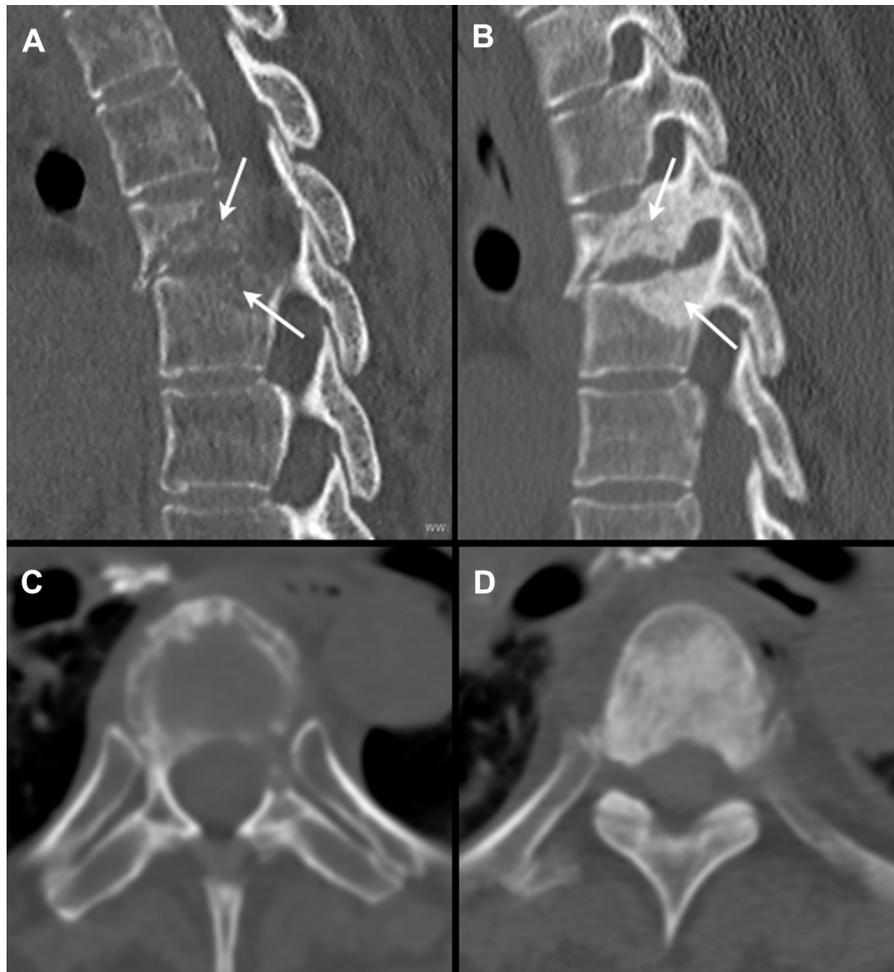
(A) Sagittal and (C) axial computed tomography (CT) scans of the thoracic spine performed 6 weeks before the attempted vertebroplasty and right before the initiation of medical therapy with denosumab, demonstrating the presence of pathological compression fractures because of lytic lesions at T5 and superior end plate of T6 (white arrows). (B) Sagittal and (D) axial CT scans of the thoracic spine performed after the attempted vertebroplasty demonstrating complete remodeling of the vertebral bodies, with the presence of markedly sclerotic lesions at the same site (white arrows).
